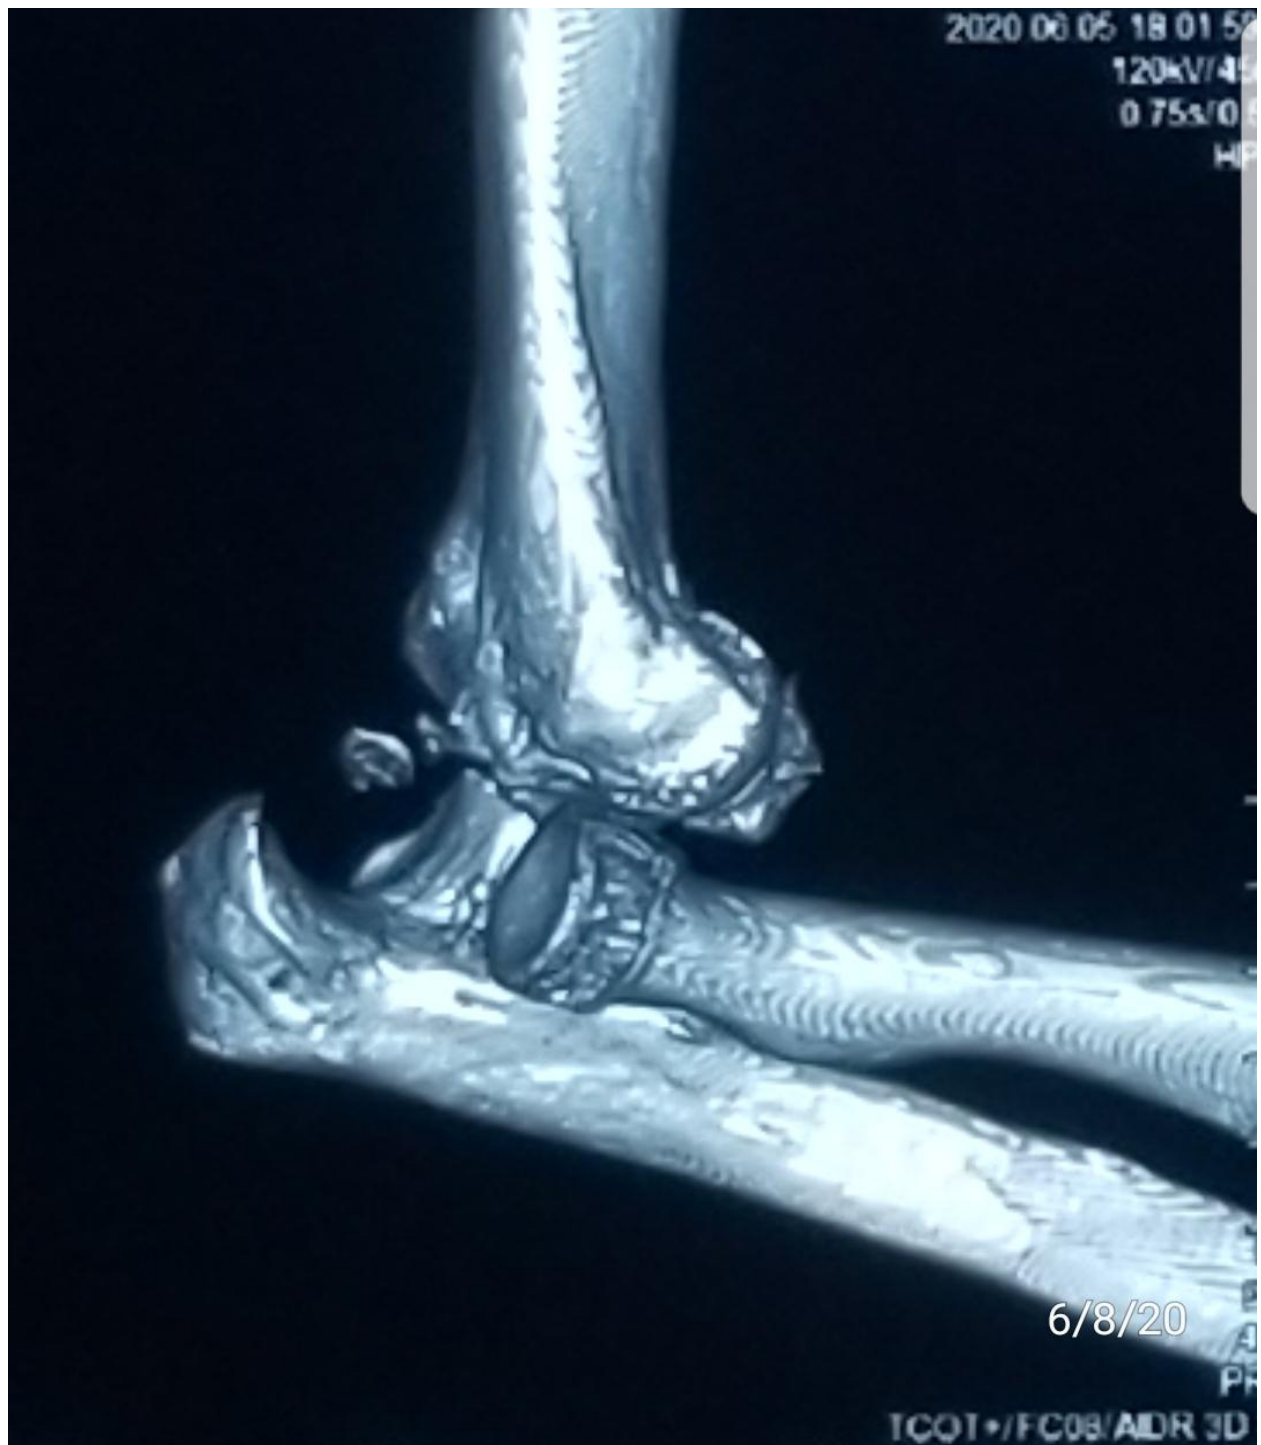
CT scan of Right Elbow showing the dislocated elbow
